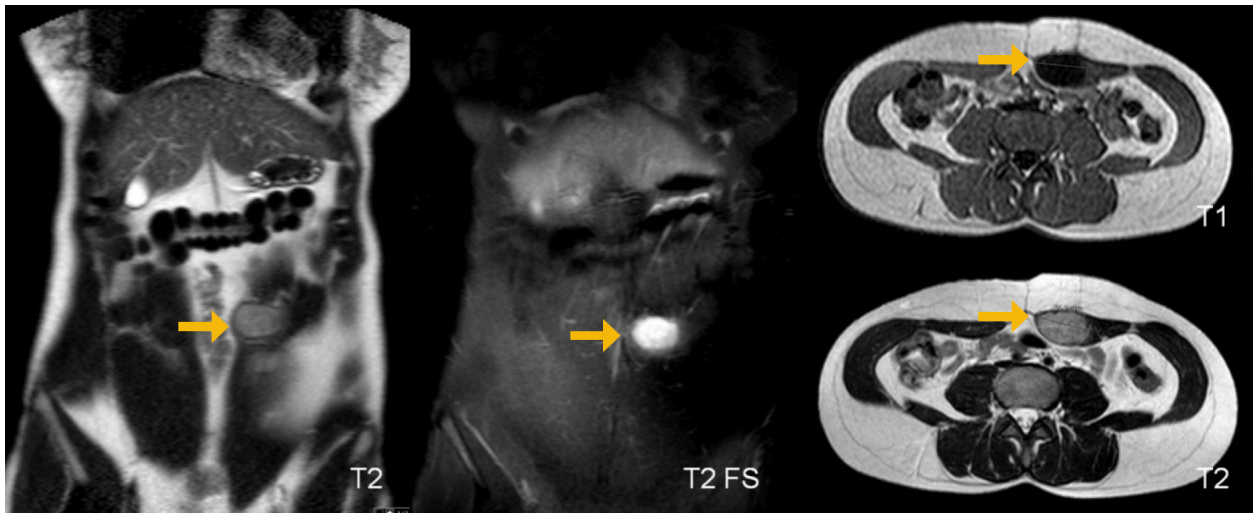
Abdominal wall fibromatosis in a 37-year-old female. MR images showing a well defined nodular lesion in the left rectus abdominis muscle (arrows) with hypointense signal on T1-weighted images, faint hyperintense signal on T2-weighted images and conspicuous hyperintense signal on fat saturated sequences.
